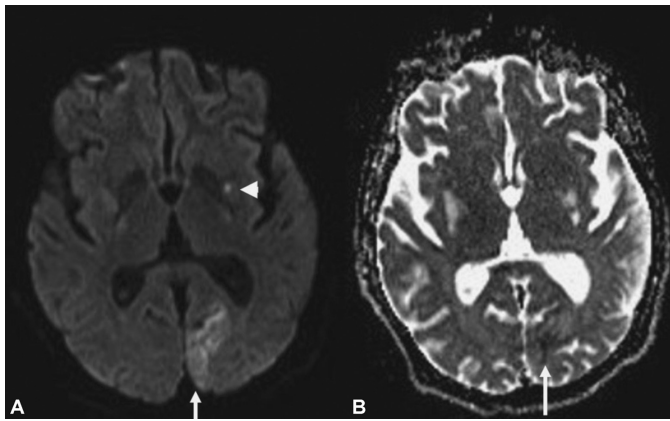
MELAS. *A:* This b1000 DWI sequence shows cortical hyperintense signal (*arrow*) extending from the left occipital pole anteriorly along the cuneus, calcarine fissure, and terminating at the lingual gyrus, with an additional hyperintense focus in the left external capsule (*arrowhead*). *B:* Corresponding ADC; mildly hypointense signal is seen within the occipital lobe (*arrow*) in this young woman.
